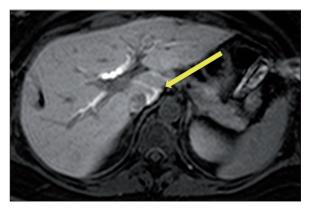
Biliary fistula and biloma. Axial T1-weighted fat suppressed image shows a biliary fistula and bile extravasation around the caudate lobe.
